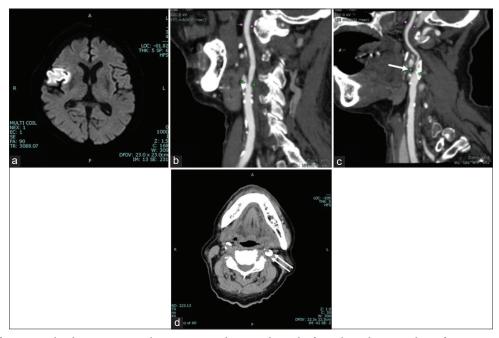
(a) Diffusion-weighted image at initial presentation showing the right frontal insulo-opercular infarction. Sagittal image of CT angiogram of (b) the right and (c) the left carotid artery, showing mild stenosis on the right and severe stenosis on the left side (arrow). (d) CT without contrast medium of the neck, showing severe calcified carotid plaque on the left side (double arrows).
